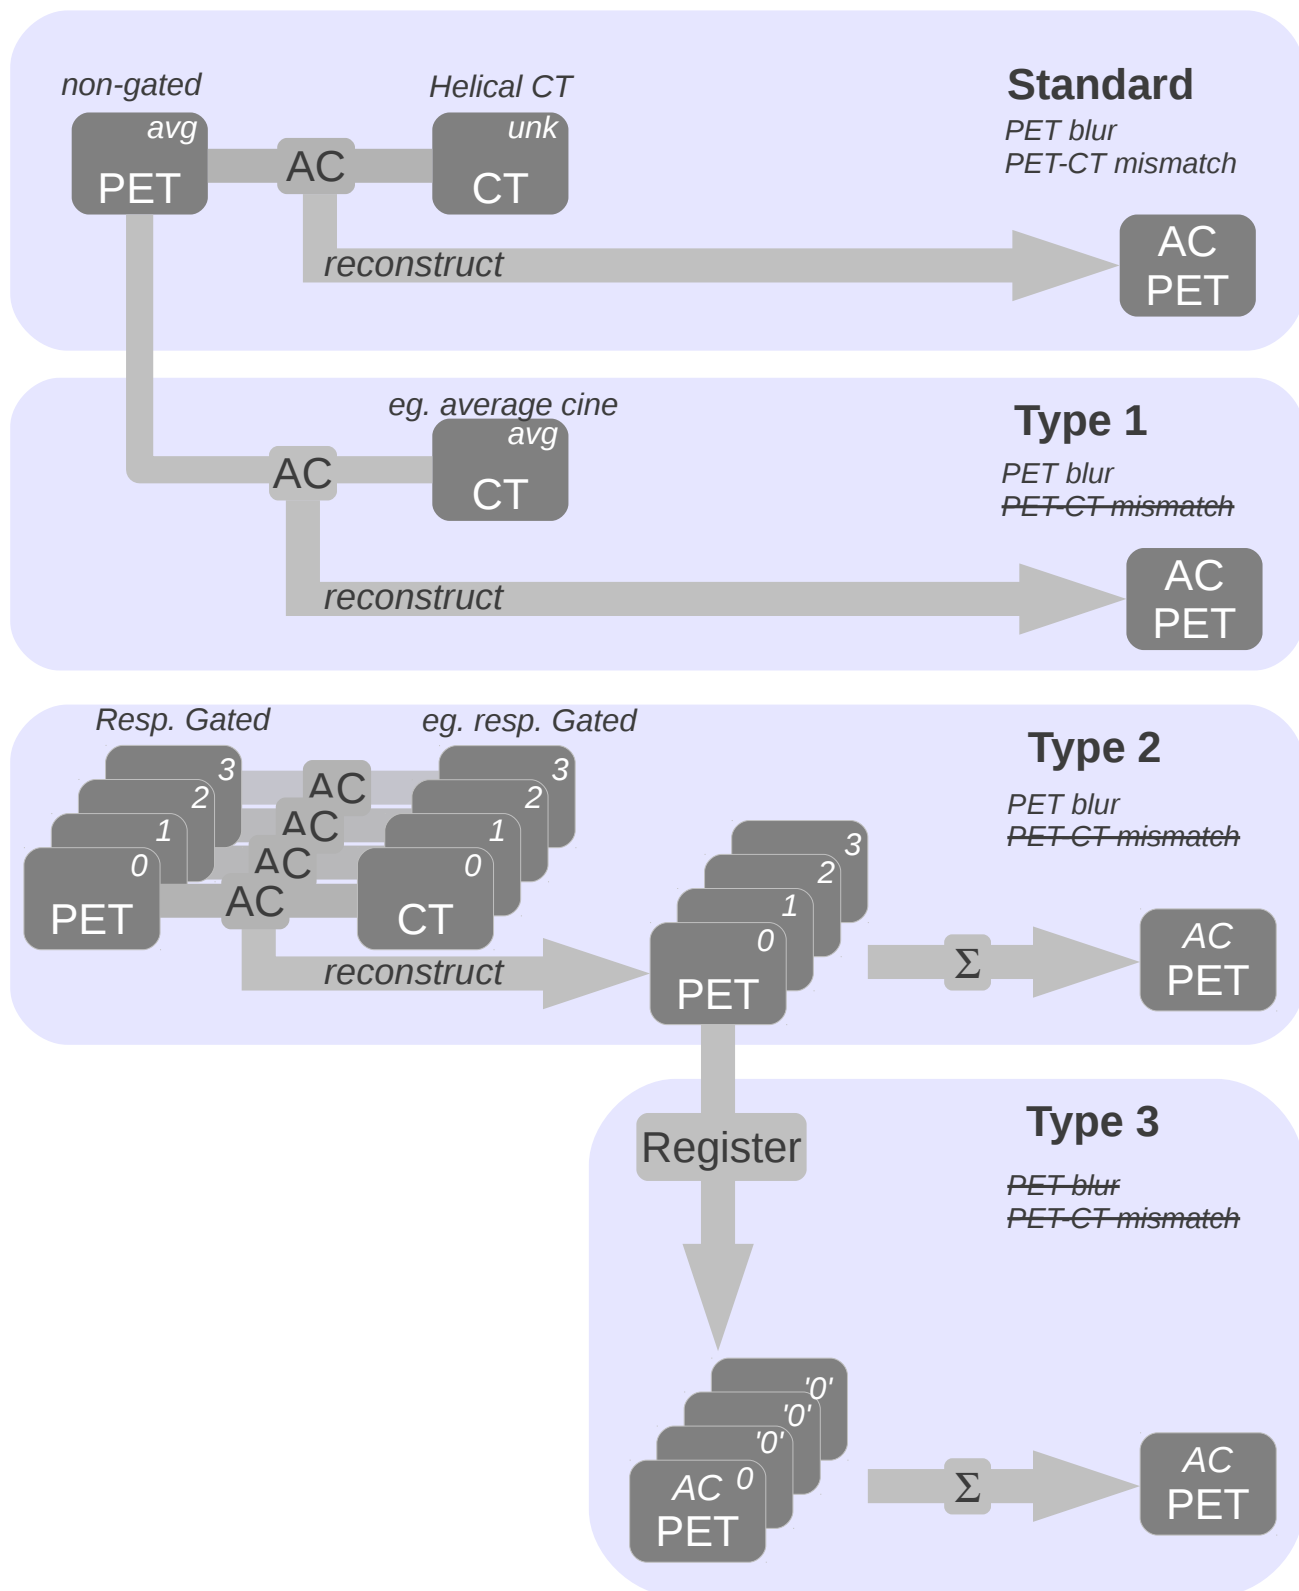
Summary of the three approaches to reducing respiratory motion artefact, including the standard method where a helical CT acquired at an unknown point in the respiratory cycle is used for attenuation correction.
